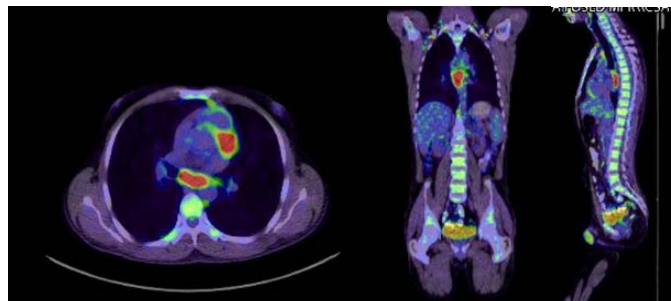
pretreatment PET scan: There is intense uptake (SUV max 19.6) projected to a 4 cm long section of the mid esophagus. Intense hypermetabolism in the mid esophagus is highly suspicious for malignancy Small separate uptake is noted with 1 cm size in the right subcarinal region. Minimal focal uptake projects to the right lung hilum.
